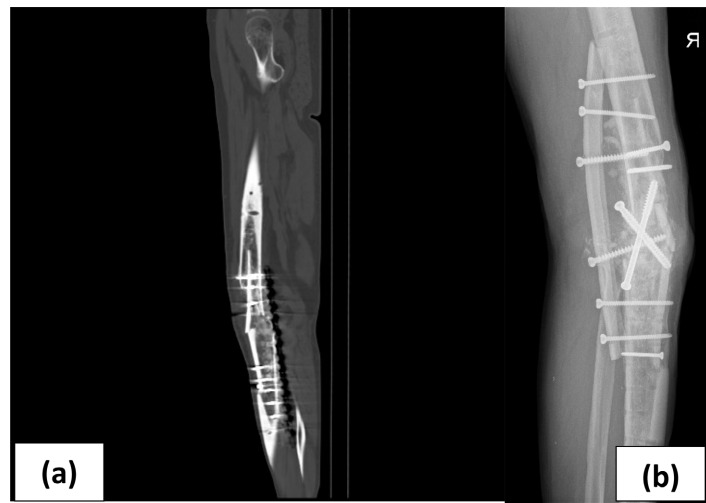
Case no. 2. Radiographs of the posterior located femur plate and broken, anteriorly placed cortical tibial graft.
